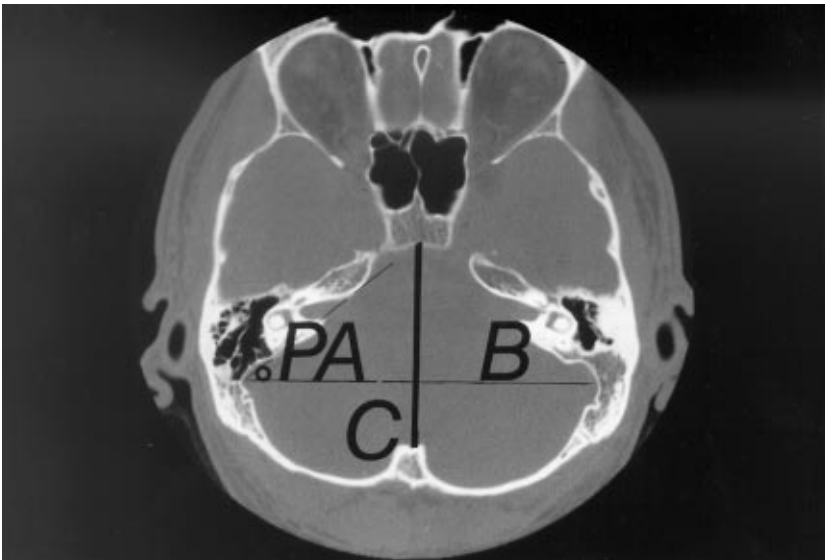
CT scan of the posterior cranial fossa showing the PA and PFI (the ratio of B/Cx100).
